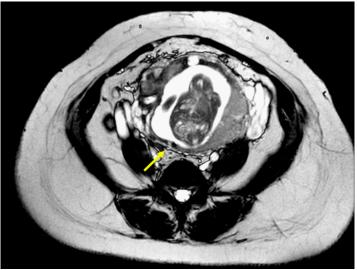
Ax BTFE MRI image at level of caesarean scar shows fetal sac with thinning of myometrium predominantly posteriorly (yellow arrow), not typical appearance of caesarean scar pregnancy.
